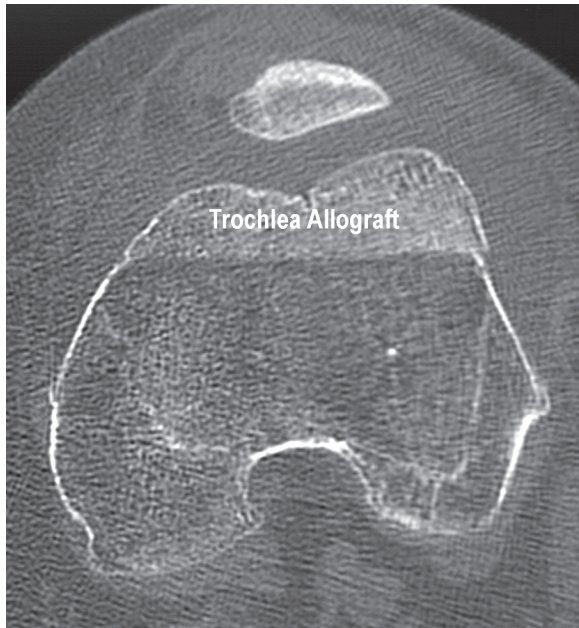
Postoperative CT at 3 months follow-up. Femoral trochlea allograft without degenerative changes or a trochlear dysplasia (FTA)
